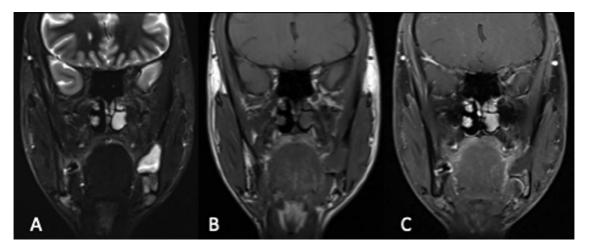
(A) Short tau inversion recovery (STIR). (B) T1-weighted image. (C) Contrast-enhanced T1-weighted image of the same case (odontogenic keratocyst) in coronal slices.
